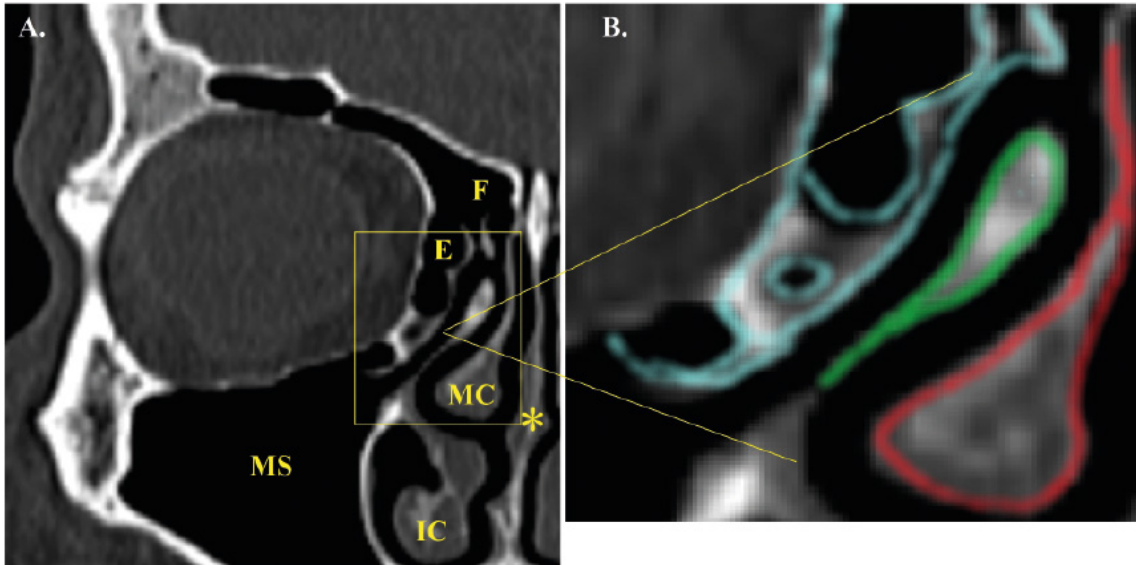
Computed tomography. (A) Image of normal anatomical structures of the nose and paranasal sinuses. The nasal septum is straight. The ostiomeatal complex and the paranasal sinuses are patent. Normal pneumatization of the paranasal sinuses. Nasal turbinates are not enlarged. (B) Image of a normal right ostiomeatal complex (blue – ethmoid sinus cells; green – uncinate process of ethmoid bone; red – middle nasal turbinate). MS – maxillary sinus; E – ethmoid sinus; F – frontal sinus; MC – middle concha; IC – inferior concha; \* – nasal septum.
